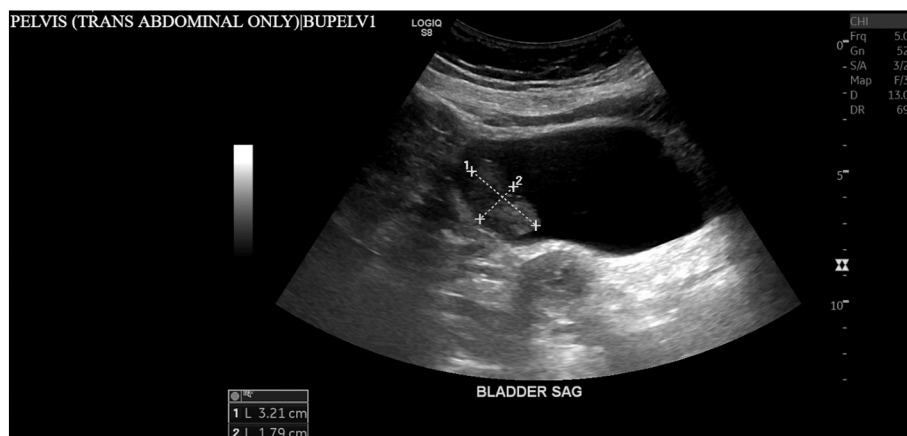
Transabdominal ultrasound of the pelvis revealing an incidental finding of a bladder mass measuring 3.2 cm in size.
